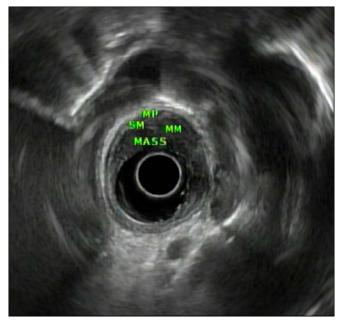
Endoscopic ultrasound of the midesophageal mass demonstrating extension past the muscularis propria.
